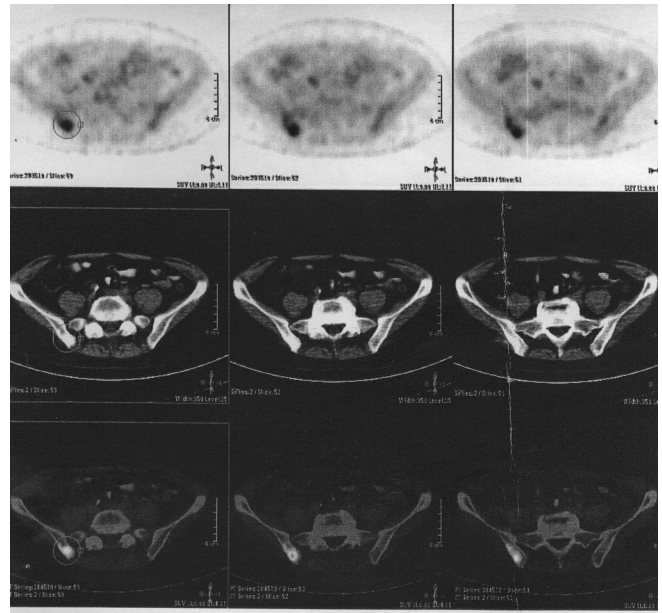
Axial CT-PET scan revealing a metastasis to the iliac crest.
